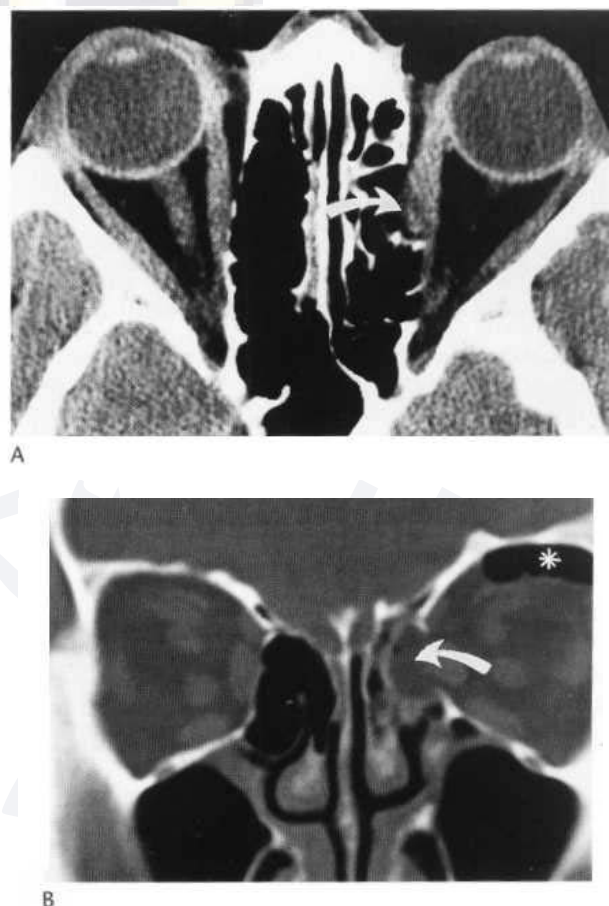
Medial blow-out fracture. Axial (A) and coronal (B) CT images demonstrate partial herniation of medial rectus muscle and orbital fat into left ethmoid air cells through fractured lamina papyracea (arrow). There is associated intraorbital emphysema (asterisk).
